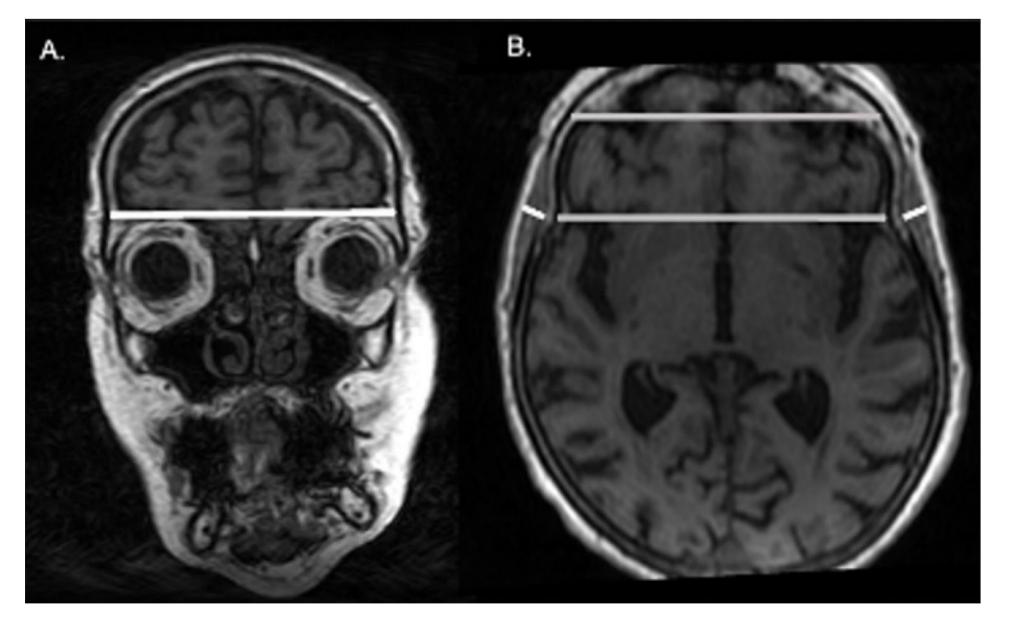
Measure of TMT in one of the participants. A representative case for the assessment of the TMT on MRI
